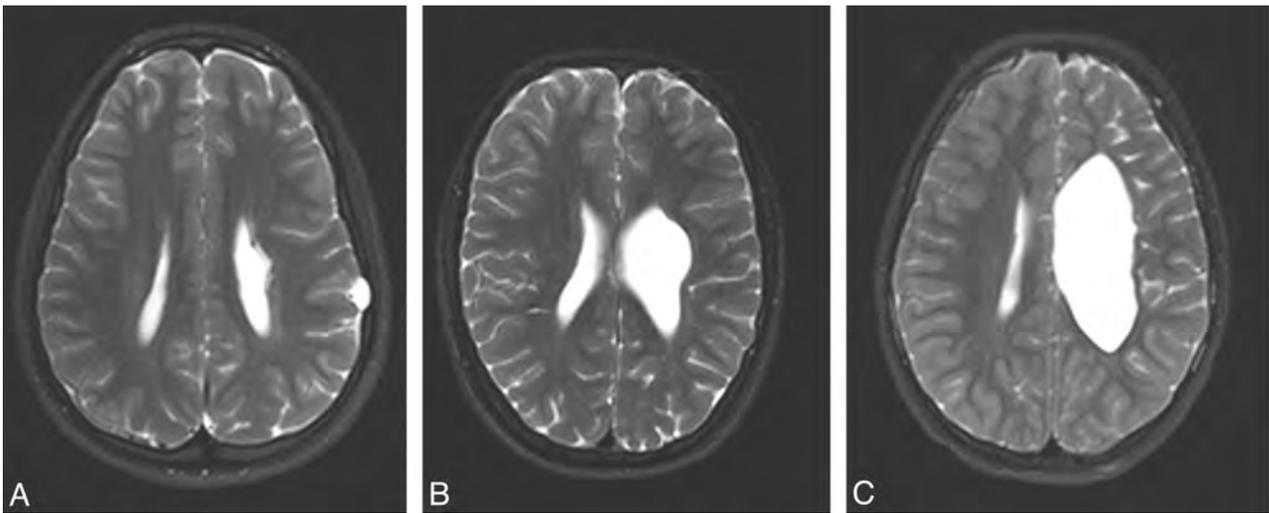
Axial T2-weighted images at the level of the lateral ventricles from 3 different patients demonstrating different levels of white matter loss: A indicates mild; B, moderate; and C, severe.
